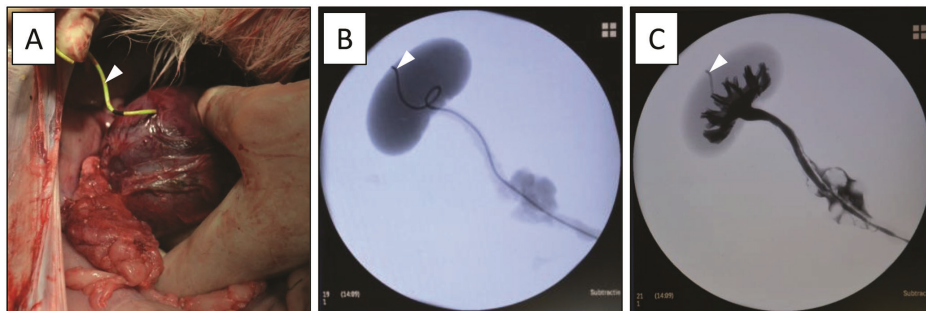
a. Macroscopic view of the right kidney after perforation by the ureteral catheter (white arrowhead). b. X-ray scan without iodinated contrast fluids. Stent is clearly visible in the system and perforates the renal cortex (white arrowhead). c. X-ray scan with iodinated contrast fluids. Contrast fills the kidney calyces and the stent can be seen in the renal cortex outside of the calyces (white arrowhead).
